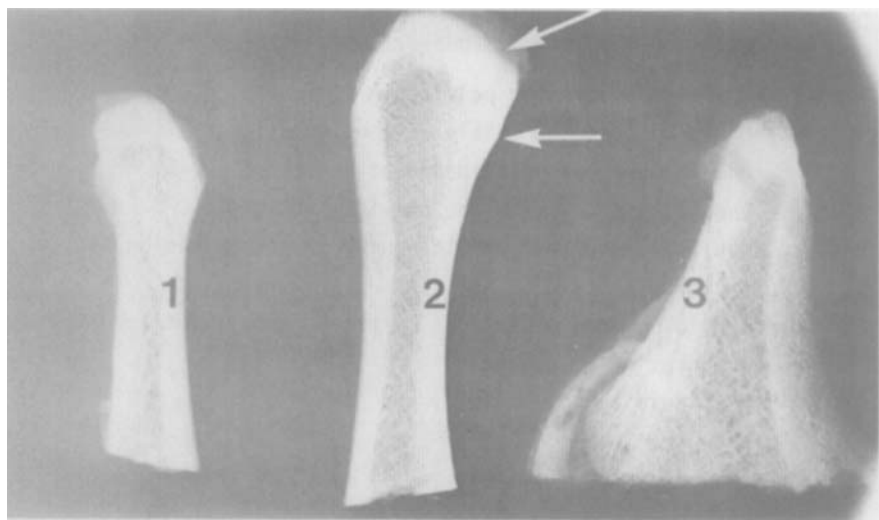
Slab radiographs of transverse sections of the iliac crest shown in Fig. 43 and removed from the areas of the bone designated 1, 2 and 3, respectively.
